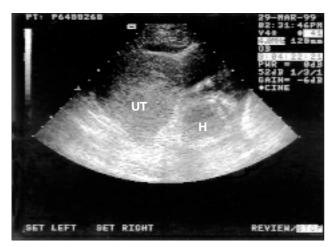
Transabdominal ultrasonogram showing foetal head (H) outside the empty uterus (UT)
